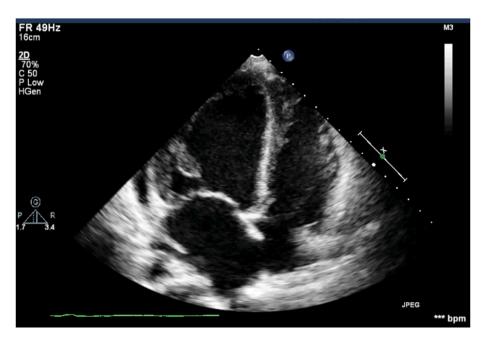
In the apical 4-chamber trantrosaic echocardiography, it is noteworthy that the thrombus previously shown completely disappeared.
